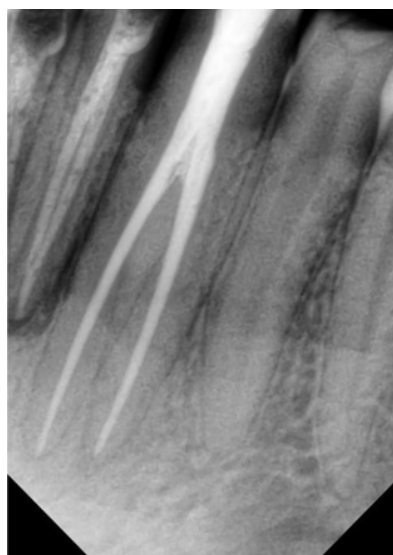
Intraoralperiapical radiograph indicating successful endodontic therapy at 3 months follow-up
